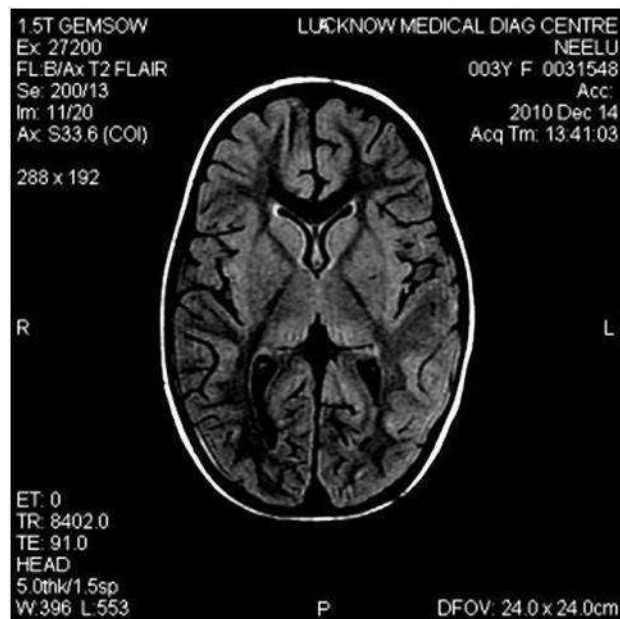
Axial T2 FLAIR image of same patient with no changes
